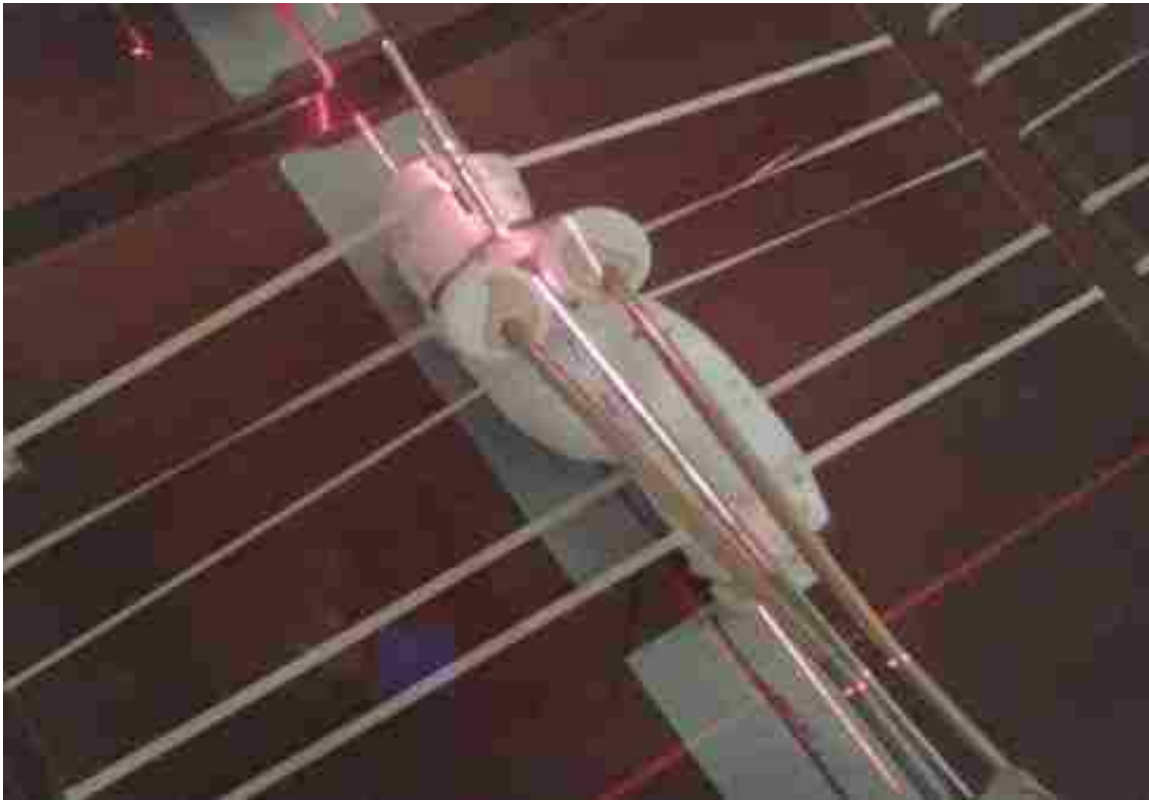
Overhead view of T&O applicator alignment with surrogate rectum structure. The T&O applicator was aligned with the overhead CT laser.
